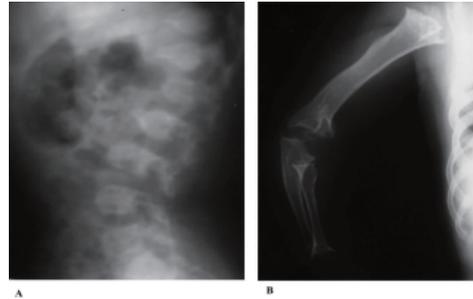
X-ray (Lateral view) of lumbar vertebrae of the father of case 15 with flat rounded vertebrae with anterior beaking and increased lumbar lordosis (A). X-ray of right upper limb of case 15 showing short irregular long bones with irregular wide metaphyses and small epiphyses (B).
